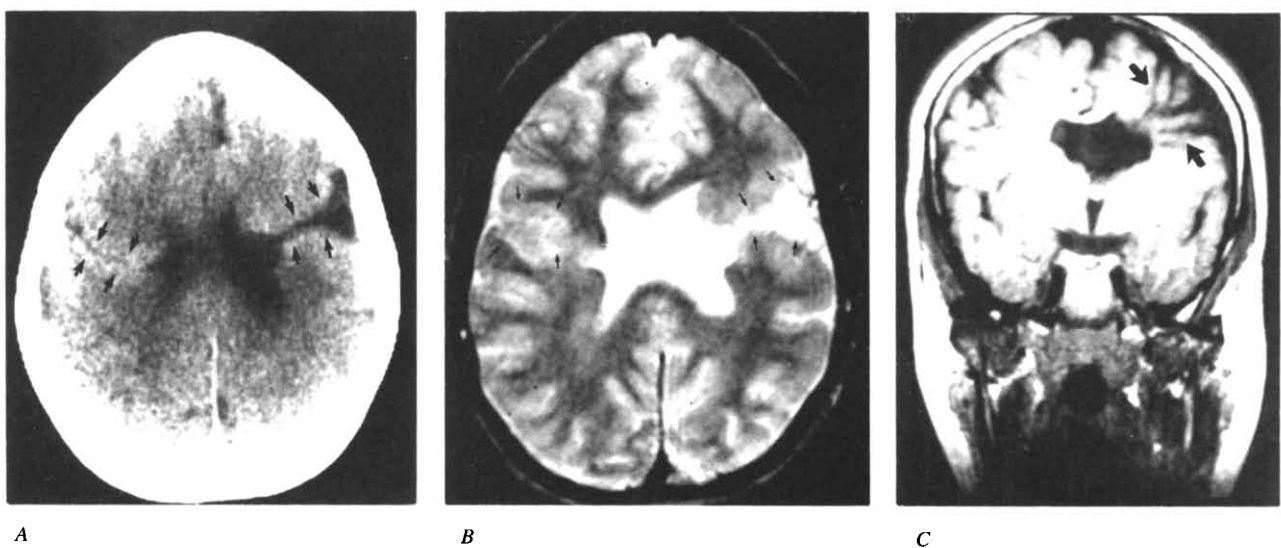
Patient 2. (A) Axial CT at the ventricular bodies demonstrates a smaller right hemispheric closed-lip schizencephaly (arrows) and a larger left hemispheric opened-lip schizencephaly (arrows). (B) Axial second echo T₂ MRI at the ventricular bodies demonstrates to better advantage the gray matter lining of the bilateral schizencephalic clefts (arrows). (C) Coronal T₁ MRI through the frontal horns reveals the gaping left hemispheric cleft (arrows) as well as an absence of the septum pellucidum and focal dilatation of the left frontal horn ventricular body.
